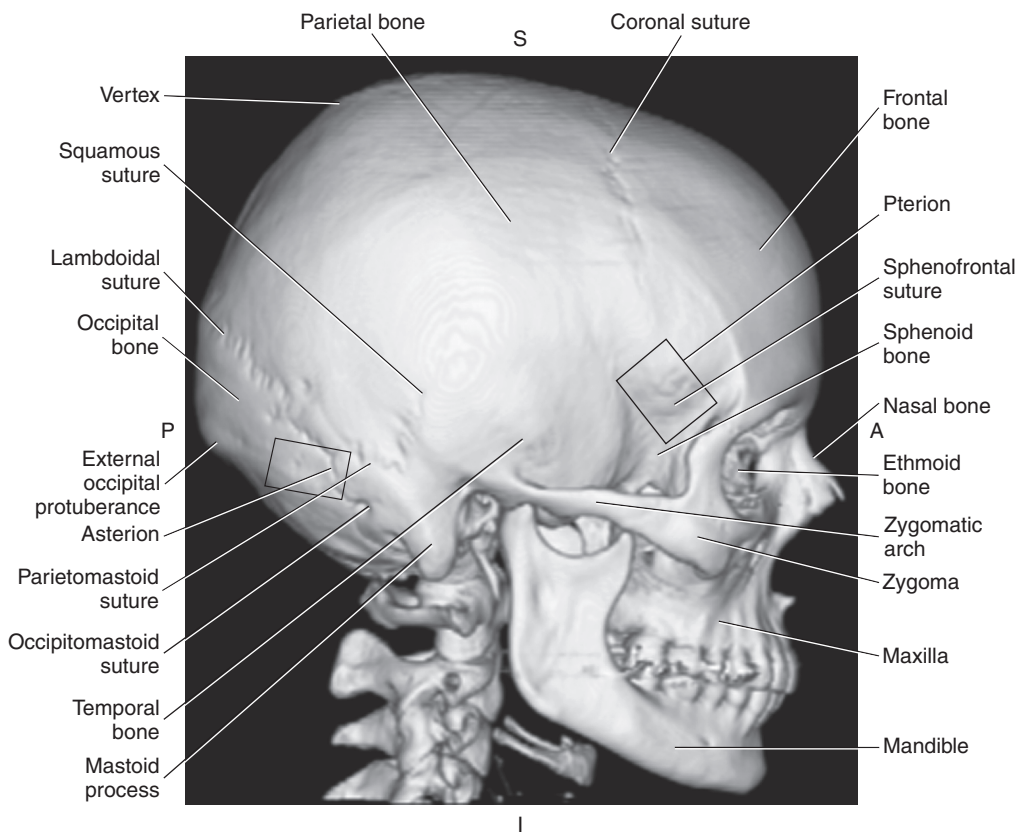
3D CT of lateral skull.
